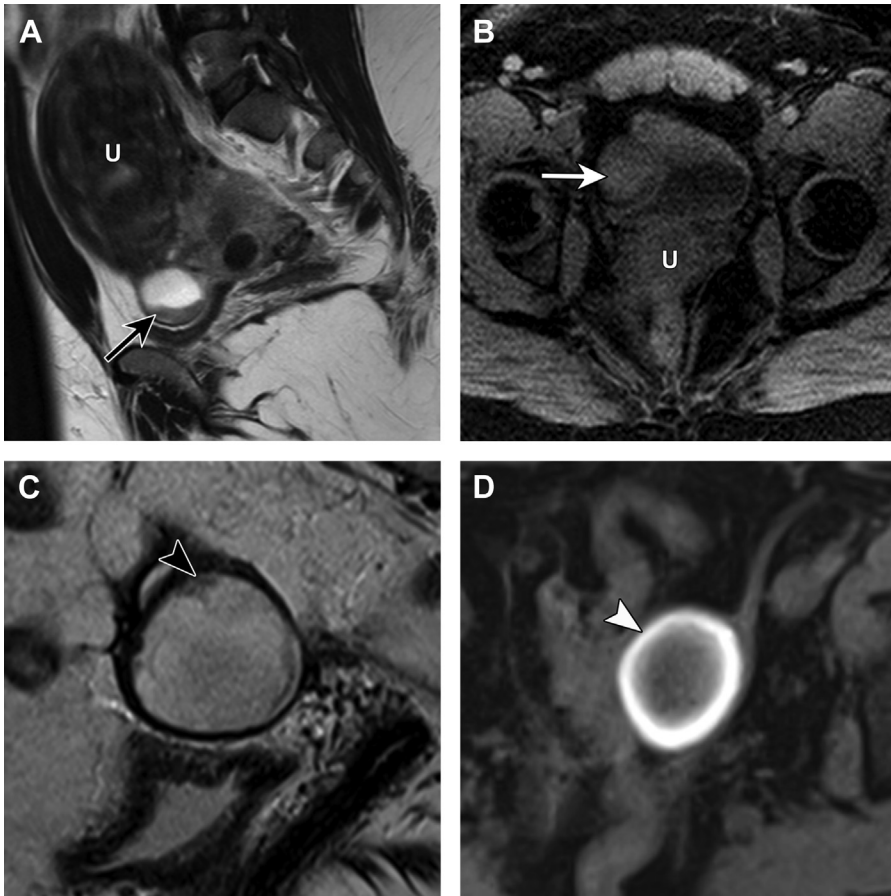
Hemorrhagic cysts in two patients (A and B vs C and D). Sagittal T2-weighted MR image (A) shows a cyst with layering hypointense signal compatible with blood clot (*black arrow*). Incidental fibroids present in the uterus (U). Axial T1-weighted MR image with fat saturation (B) shows mild heterogeneous hyperintense signal within the hemorrhagic cyst at the level of the blood clot (*white arrow*). Sagittal T2-weighted MR from a different patient with a hemorrhagic cyst (C) shows mild internal T2-weighted hypointensity (*black arrowhead*). Axial T1-weighted image with fat saturation from the same patient (D) shows peripheral T1-weighted hyperintense signal (*white arrowhead*). Note the T2-weighted hypointensity in both cases is not as hypointense as for the T2 dark spot sign (see Fig. 4).
